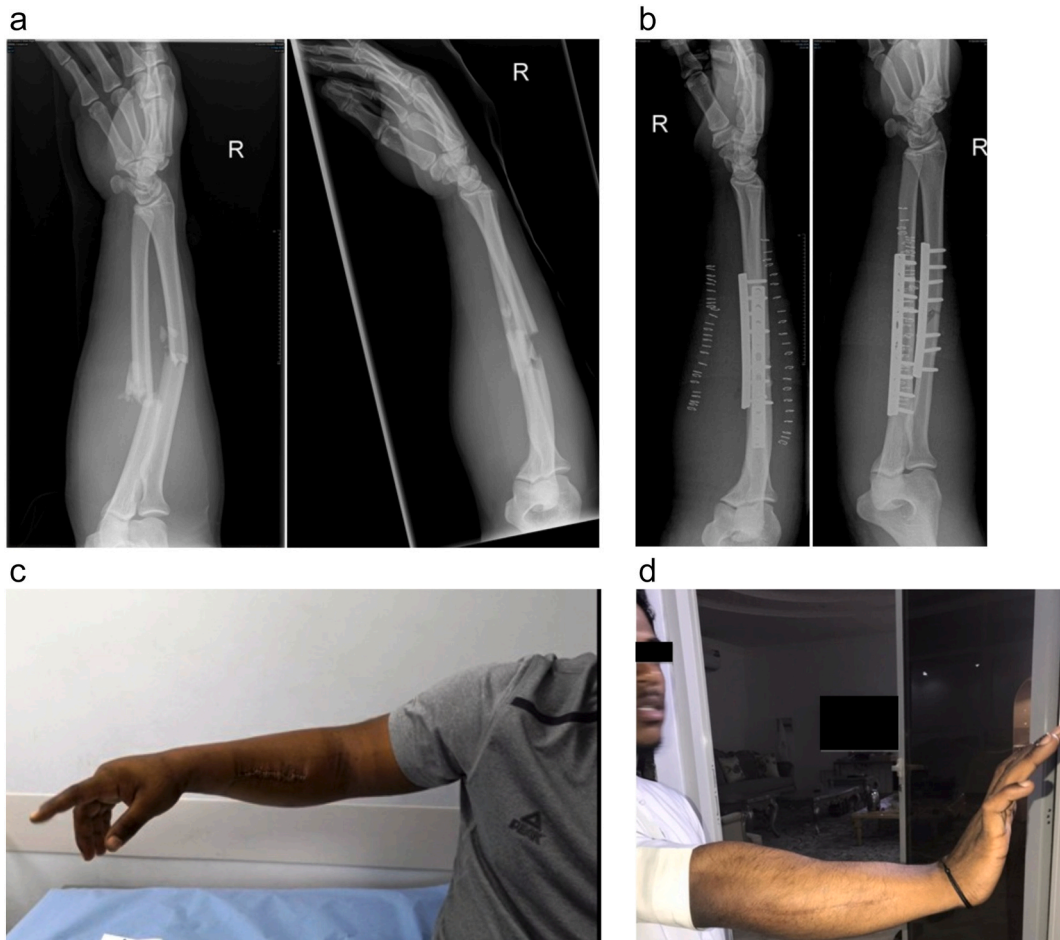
a- Injury radiographs showing Grade 1 open fractures right radius and ulna
